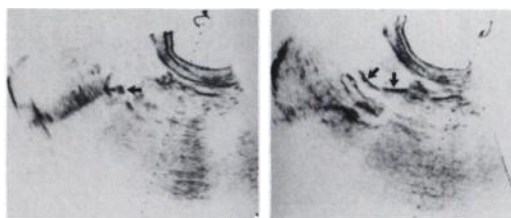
Biliary ultrasonography. Gallbladder gives a single large internal echo (arrow) with prominent posterior shadowing, compatible with cholelithiasis (left). There may be other associated small stones. Common bile duct (two arrows) measured 12 mm, which indicates moderate dilation (right).
